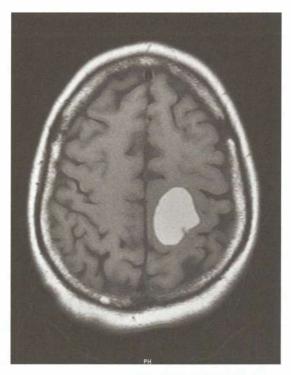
MRI brain showing metastasis from bronchogenic carcinoma
